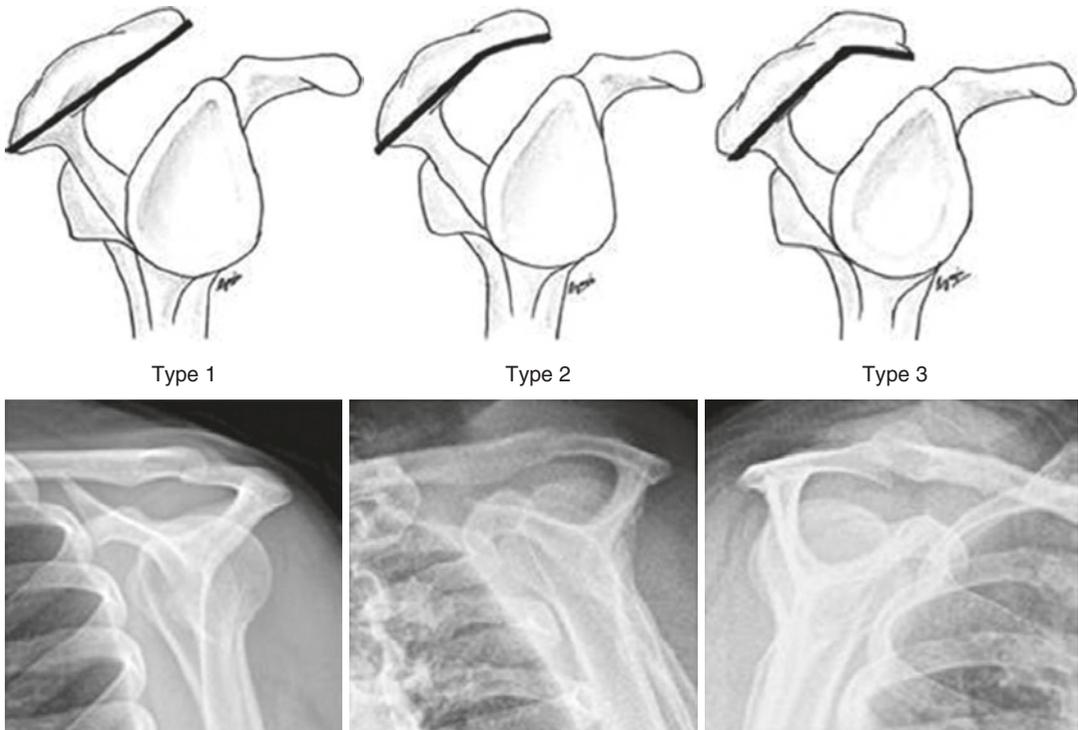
Bigliani's acromion classification of the undersurface of the acromion with corresponding radiographs [29]
